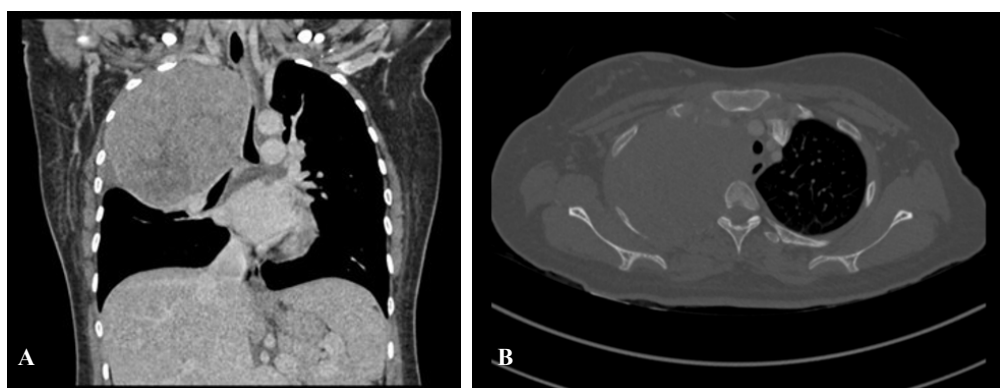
Computed tomography of the thorax (A) Coronal image demonstrates a large, heterogeneously enhancing right apical mass causing mediastinal shift and compression of adjacent structures. (B) Axial image (bone window) widening of right T3 neuroforamina (white arrow).
